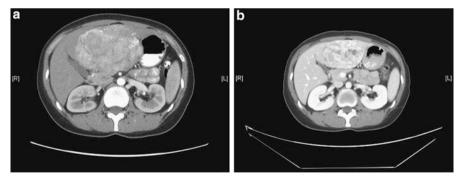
CT response of a recurrent angiomyolipoma (PEComa family of tumors) to sirolimus 4 mg oral daily. (a) Pretreatment,  $12.6 \times 7.6$  cm mass; (b) after 3 months, mass size  $9.1 \times 5.6$  cm
